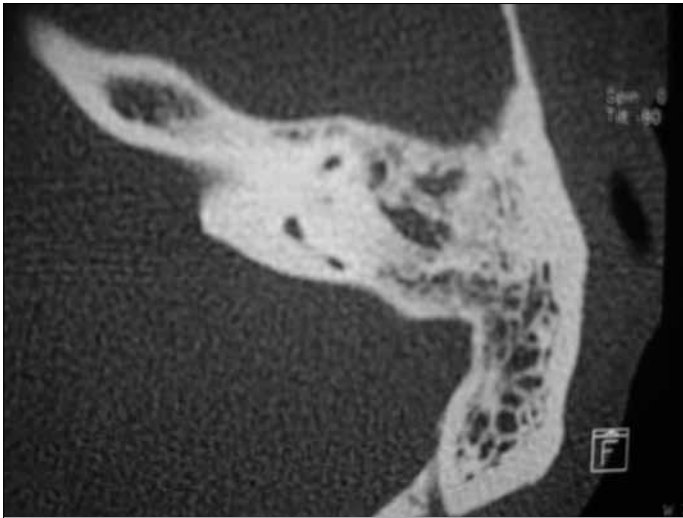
Axial CT scan of right temporal bone
